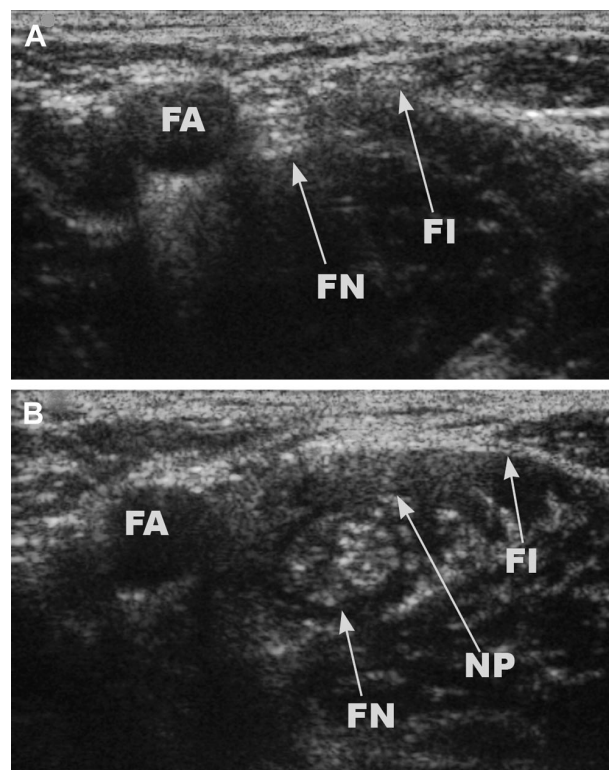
Appearance of the femoral nerve on ultrasound before injection of local anesthetic (A) and after completion of injection of local anesthetic (B) (shows swelling of the nerve). FA = femoral artery; FI = fascia iliaca; FN = femoral nerve; NP = needle path.
